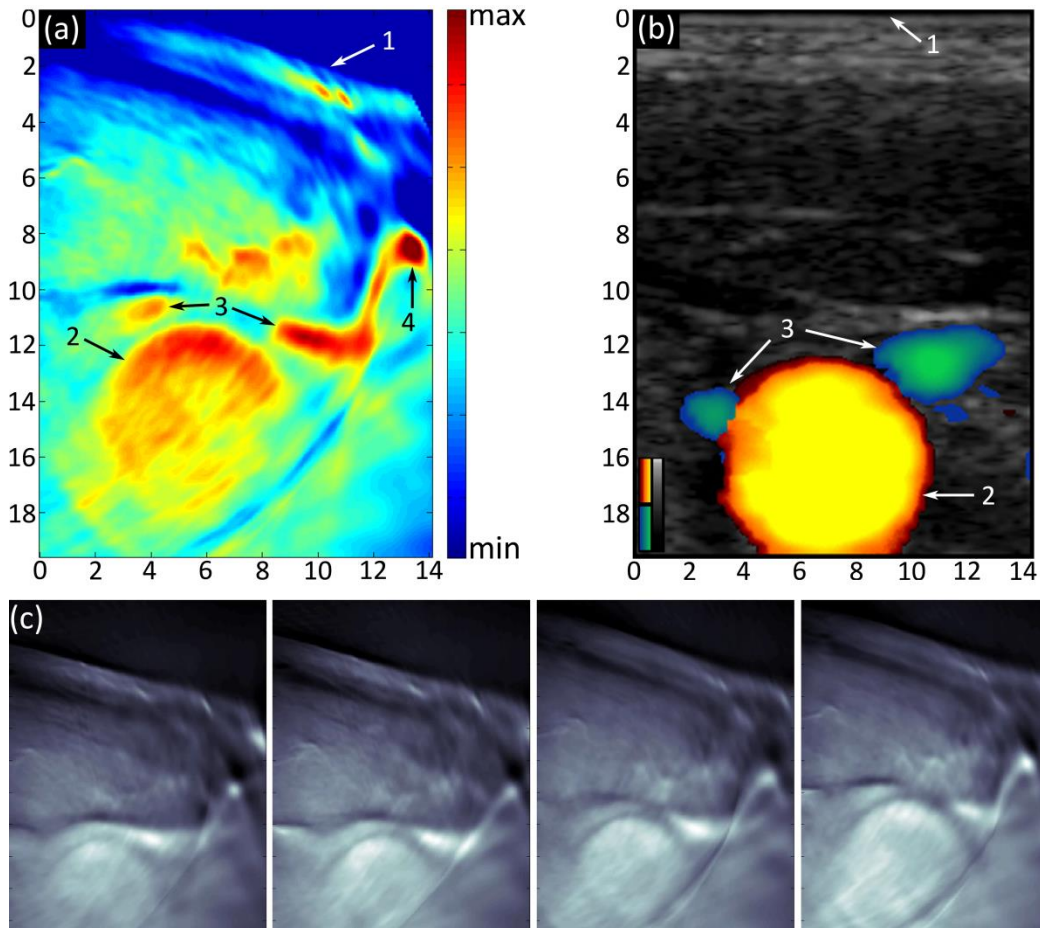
Cross-sections showing cardio-vascular features of a female volunteer at the lower neck level – axes are given in mm. (a) Optoacoustic image from the initial curved array prototype. (b) Directional ultrasonography image, overlaid on standard ultrasonography image in gray, indicating positive flow in yellow/red; negative flow in green/blue. Annotations: 1.Skin surface; 2.Common carotid; 3.Internal jugular vein; 4.External jugular vein. (c) Screen capture of video sequence showing carotid enlargement due to heartbeat.
